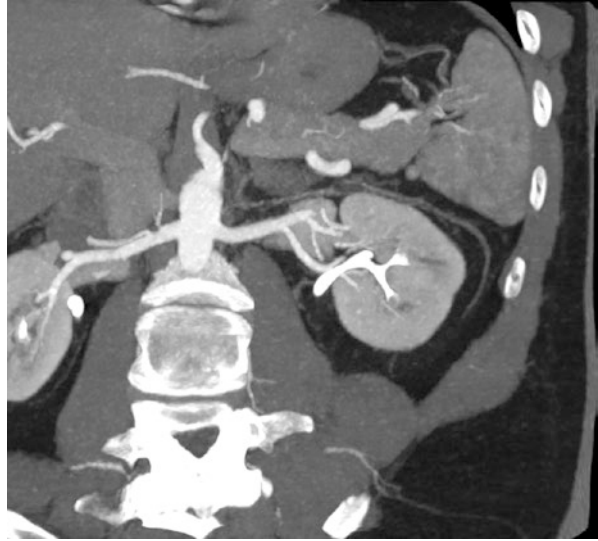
Coronal CT MIP image in the arterial phase demonstrates a superior polar artery to the left kidney in a potential donor. This patient ultimately donated the left kidney uneventfully. The superior polar artery seen in this image was sacrificed during surgery
